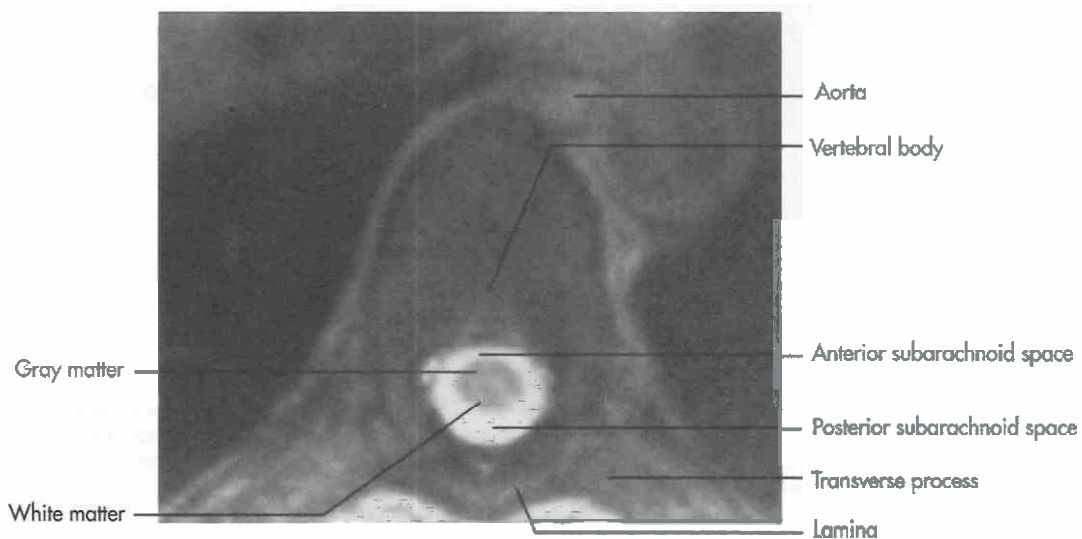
Axial T2 MRI at the midthoracic level. The thoracic cord has a more rounded appearance. Note the larger subarachnoid space posteriorly with high signal intensity in this T2 study.
